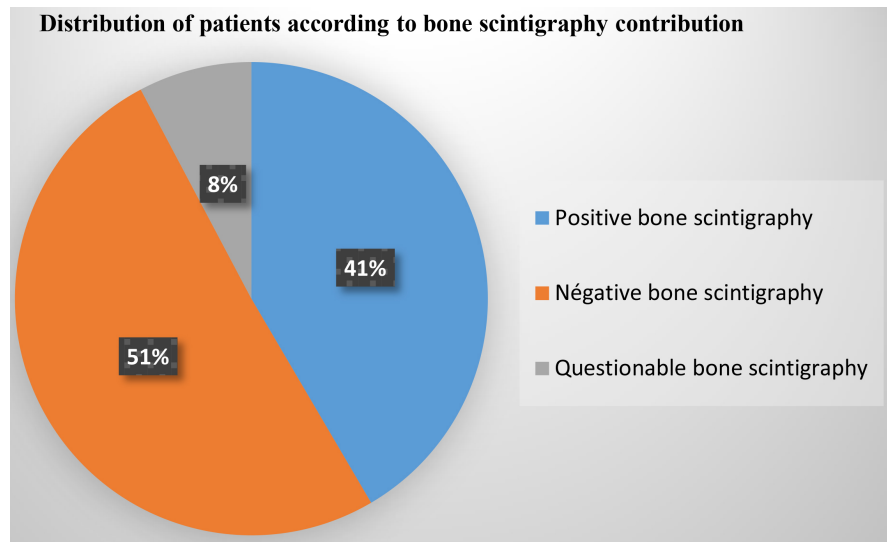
Distribution of patients according to bone scintigraphy contribution.
